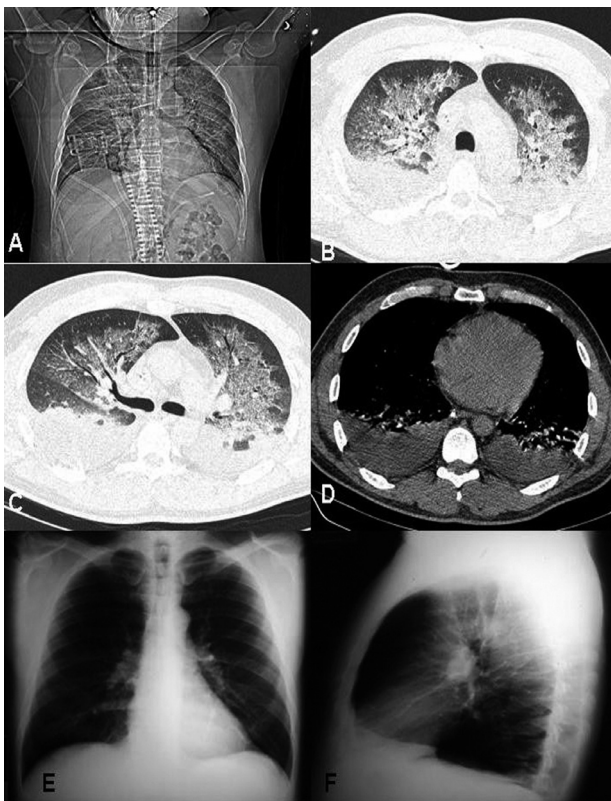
(A) Digital chest radiography showing bilateral alveolar and interstitial opacities in perihilar and peribronchovascular regions; (B) and (C) chest CT images at aortic and carina levels showing bilateral peribronchovascular opacities, and inspissation of septal and intralobular interstitium; (D) bilateral pleural effusion on CT; (E) and (F) normal findings showed on the chest radiograph on recovery
